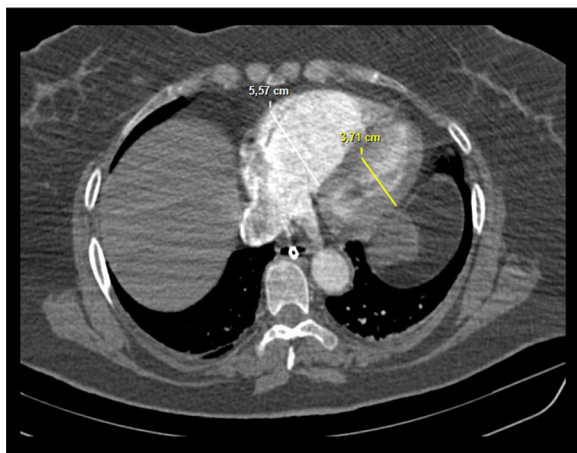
Axial contrast- enhanced CT of the thorax demonstrates thrombus in the right main pulmonary artery and left pulmonary artery branches. An area of pulmonary infarct is seen in the posterior segment of the right lung.
